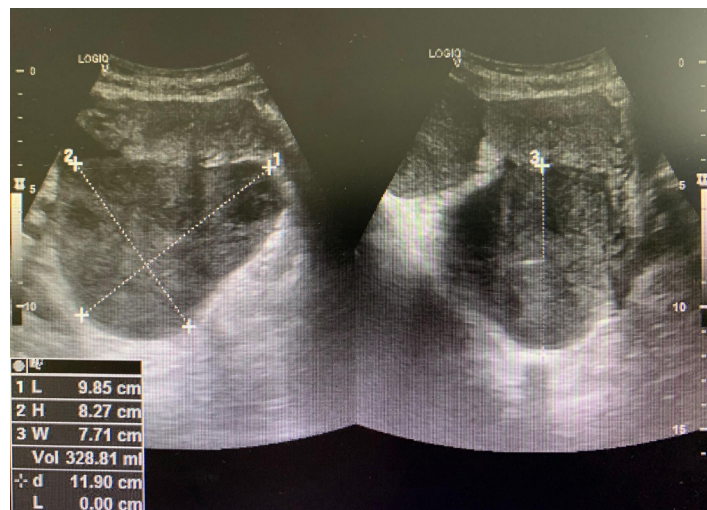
Transvaginal ultrasound showing two complex images, predominantly solid, with well-defined boundaries, and large solid areas, intensely vascularized on color Doppler.
